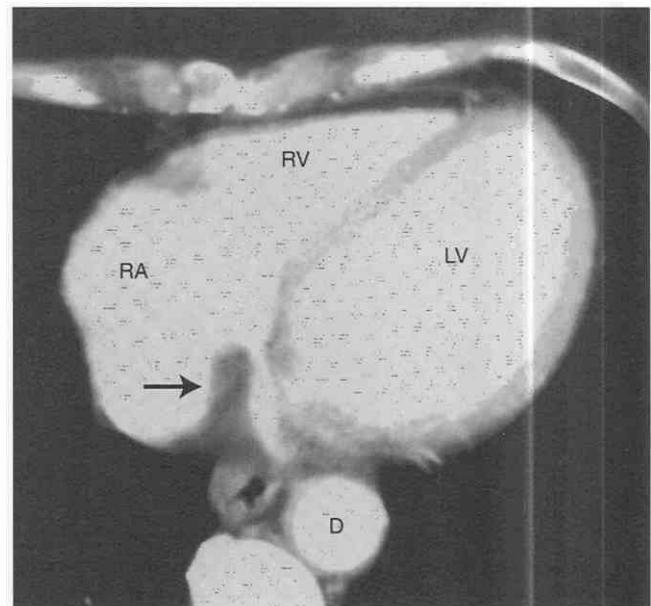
Prominent eustachian valve. Axial contrast-enhanced CT image shows a finger-like soft tissue projection within the right atrium (*arrow*). A prominent eustachian vein was detected by echocardiography. D, descending aorta; LV, left ventricle; RA, right atrium; RV, right ventricle.
